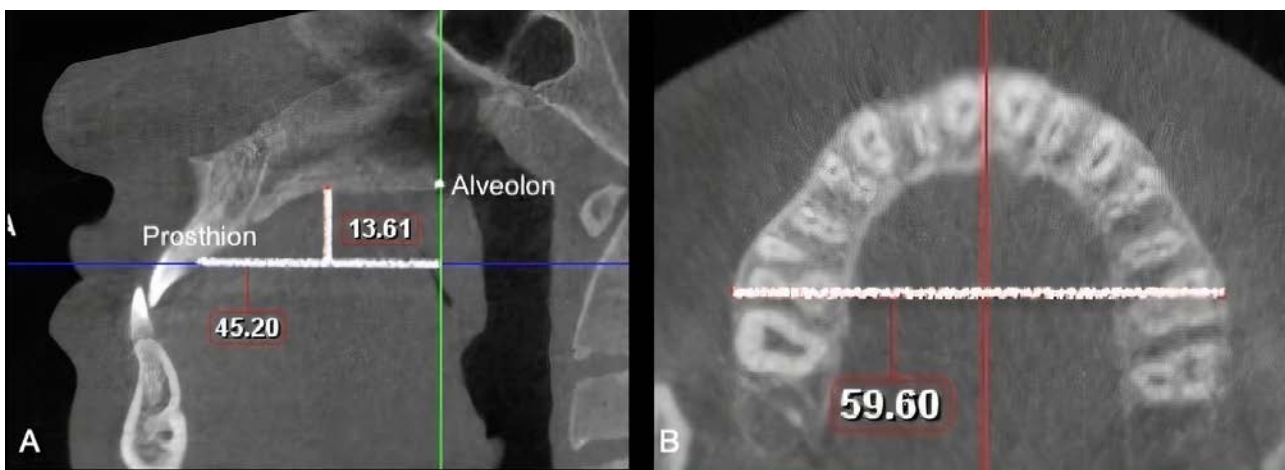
A. CBCT image showing the Maxilla-alveolar length and Depth of the palate; B. CBCT image showing the maxilla-alveolar breadth
